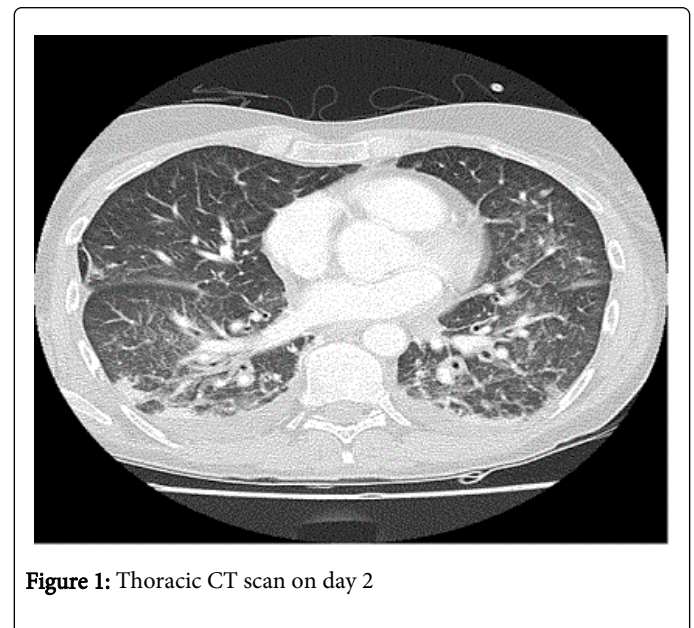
Thoracic CT scan on day 2
